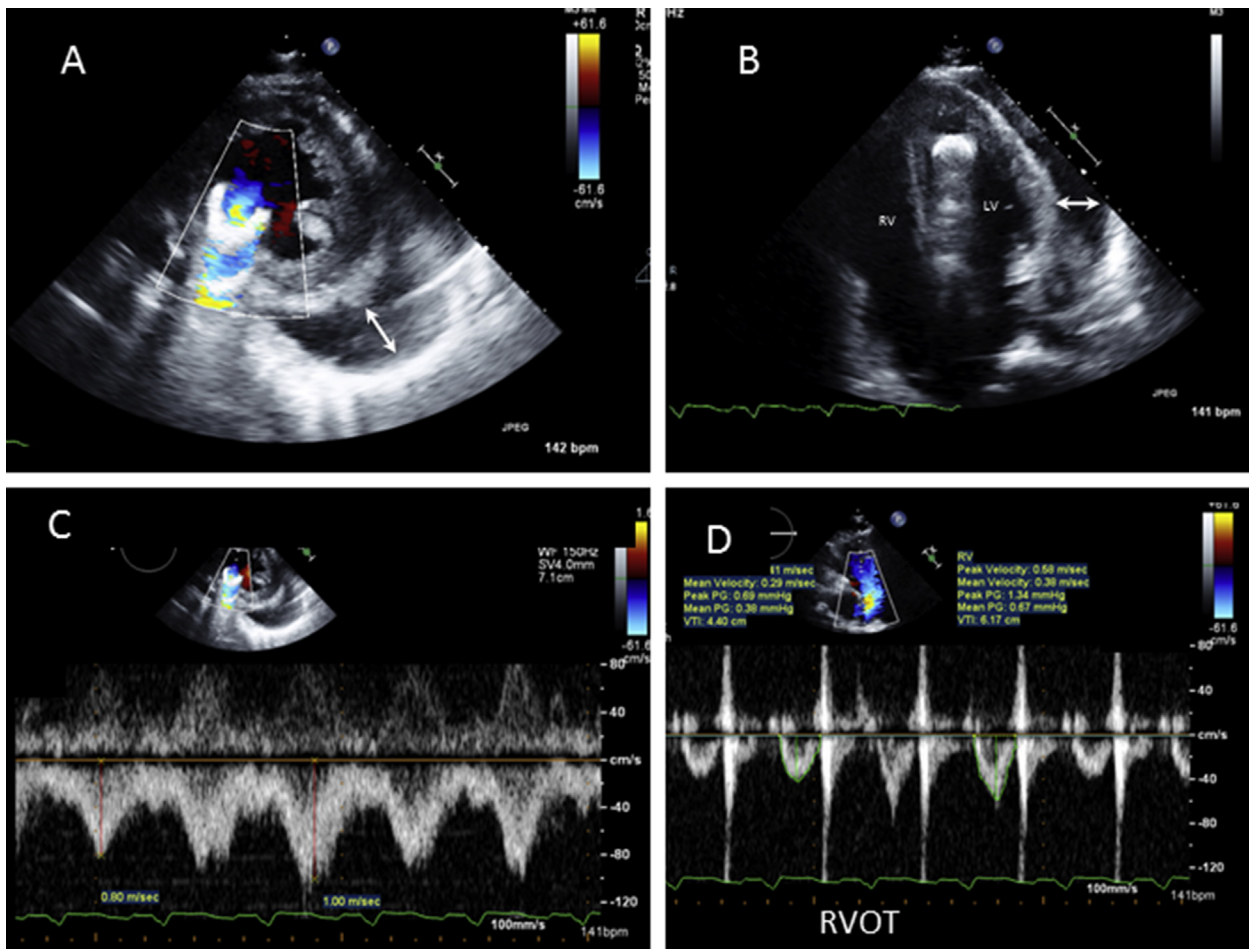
Tamponade after LVAD implantation was suspected because of low LVAD flow unresponsive to speed changes. A large, loculated pericardial effusion is seen posterolateral and lateral to the left ventricle (arrows). (A) parasternal short-axis view. See also [Video 43](#). (B) The apical 4-chamber view ruled out signs of RV failure. See also [Video 44](#). (C) Spectral Doppler examination of the inflow cannula ruled out inflow obstruction. (D) Pulsed Doppler evaluation of the RVOT shows very low VTIs (4-6 cm) at a high pump speed of 9000 rpm (HM-II). Although suggested in views C and D, respirophasic flow changes in flow velocities are frequently absent in LVAD recipients.
